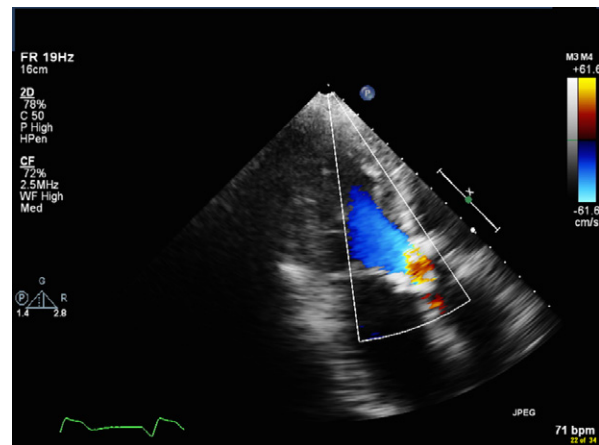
At the 2-year follow-up evaluation, transthoracic echocardiogram (apical 3-chamber view) shows no evidence of erosions on Mitroflow valve leaflets.
